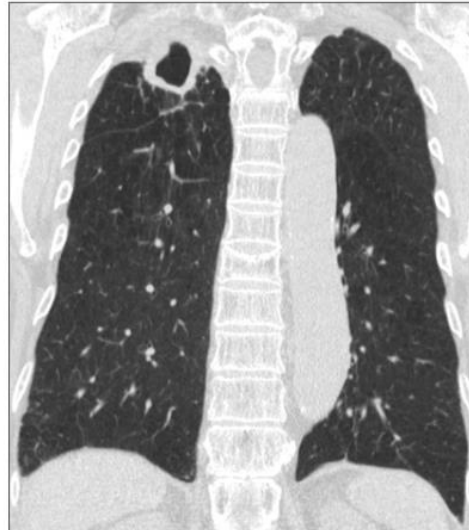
Fibrocavitary type of NTM. CT scan of a 73-year-old male patient with NTM pulmonary disease caused by *Mycobacterium intracellulare* shows cavitation in the right upper lobe accompanied by emphysema in both lungs. (Source: Ryu, 2016)
